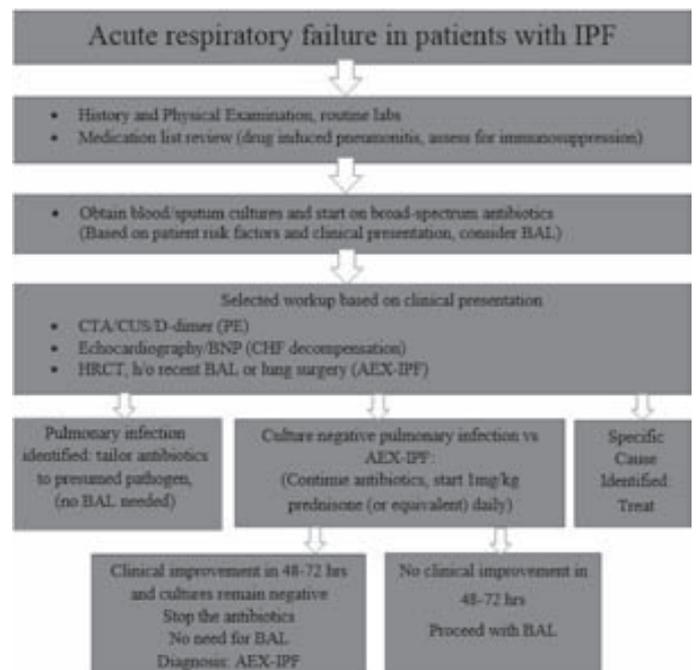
Suggested algorithm for the management of patients with IPF who present with acute respiratory failure. IPF-idiopathic pulmonary fibrosis, BAL-bronchoalveolar lavage, CTA-computer tomographic angiography, CUS-compression ultrasonography, PE-pulmonary embolism, BNP-brain natriuretic peptide, CHF-congested heart failure, AEX-IPF-acute exacerbation of idiopathic pulmonary fibrosis.
